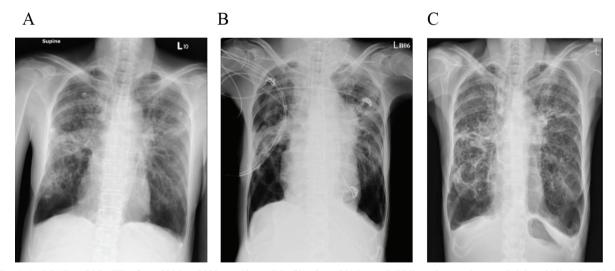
Serial Chest Plain Film from 2016 to 2022. A. Chest plain film from 2016 revealed bilateral upper lung and right middle lobe (RML) fibrotic changes with bronchiectasis and bilateral lower lung emphysematous changes. B. Chest plain film in 2020 revealed right-side pneumothorax and an endotracheal tube in situ. Bronchiectasis, and fibrotic and emphysematous changes were observed in bilateral lung fields. Consolidations in bilateral upper lung fields, and the RML and left lower lobe (LLL) showed progression. C. Chest plain film in 2022 revealed that the fibrotic changes and bronchiectasis in the bilateral upper lung fields had remained stable, whereas the consolidation had resolved.
